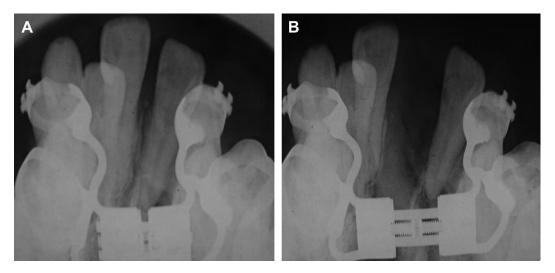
(A) An occlusal radiograph of a patient who had a right-sided unilateral cleft palate and alveolus and a transverse deficiency of the maxilla. A traditional tooth-borne palatal distractor was applied to the maxilla and an osteotomy performed in the midline between the two central incisors. (B) Note the diastemma that has developed between the maxillary central incisors, which is the site of the palatal DO in this patient who had cleft lip and palate. This intersegmentary gap is visible before the consolidation phase.
